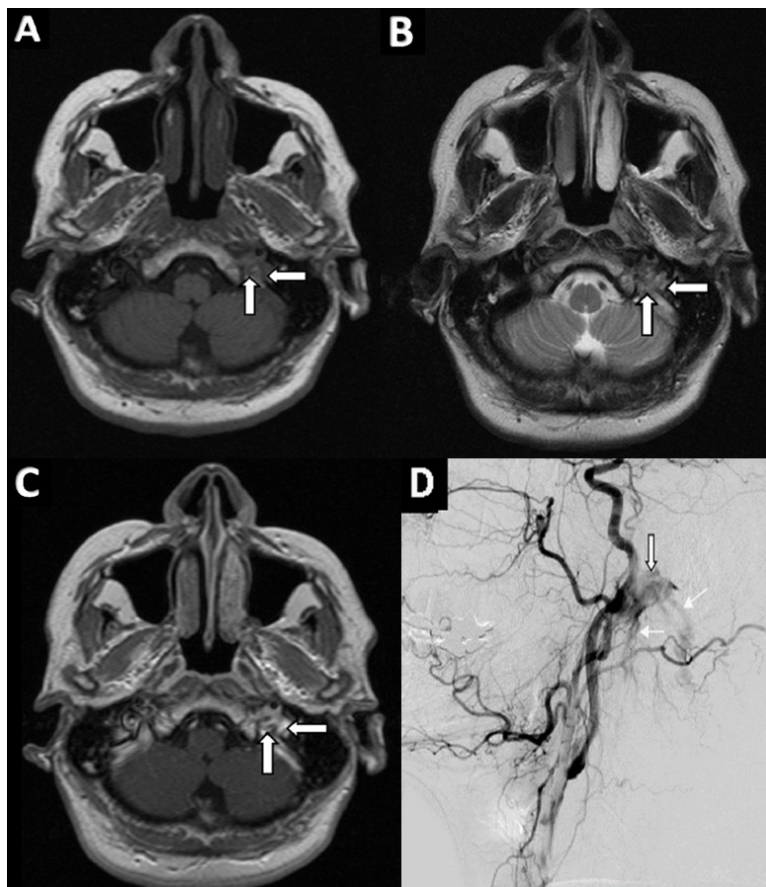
A and B: Baseline brain MRI on T1W and T2W, respectively, reveal a 20×12×10 mm mass with signal flow voids and salt and pepper appearances in the left jugular foramen (thick white arrows). C: Brain MRI on T1W with contrast demonstrates avid enhancing lesion in the left jugular foramen (thick white arrows). D: Super selective ascending pharyngeal artery angiogram shows a sizeable vascular mass with intense tumor blush (thick white arrow) and early draining veins (thin white arrows).
